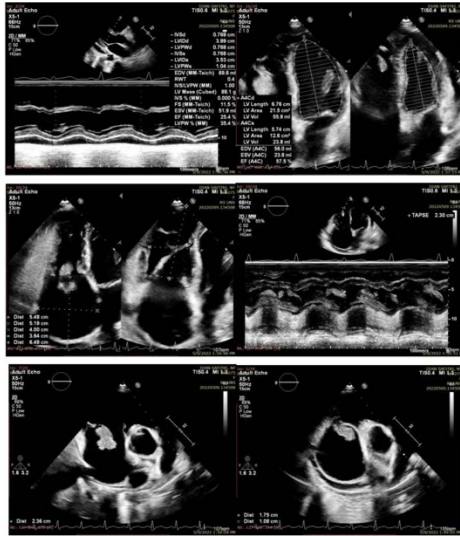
Transthoracic Echocardiography of the patient before intervention surgery.
